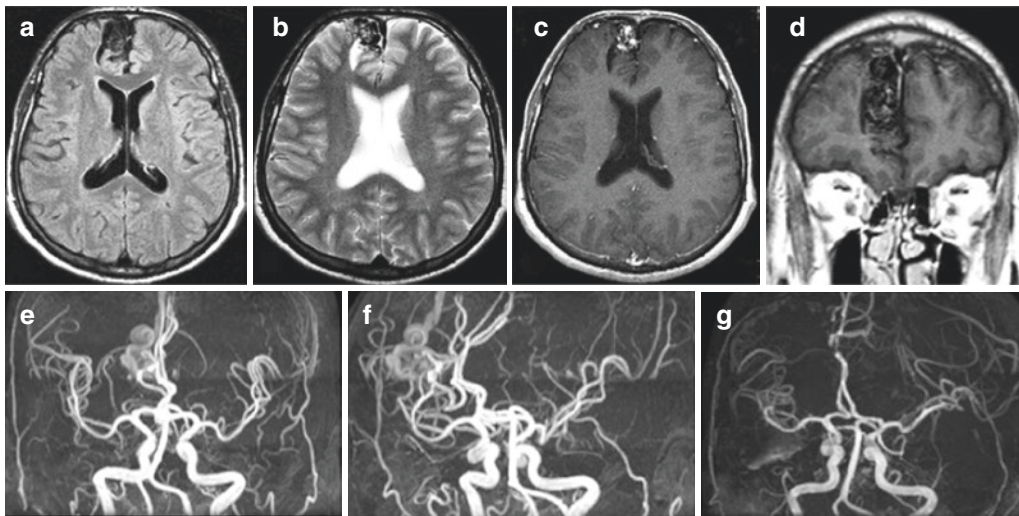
Right frontal parasagittal AVM in a 34-year-old man. The patient presented with the complaint of headache. His neurological examination was normal. Preoperative T1- and T2-weighted axial MRIs without contrast (a, b) and T1-weighted axial, coronal MRIs (c, d) with contrast show AVM in the right frontal parasagittal
